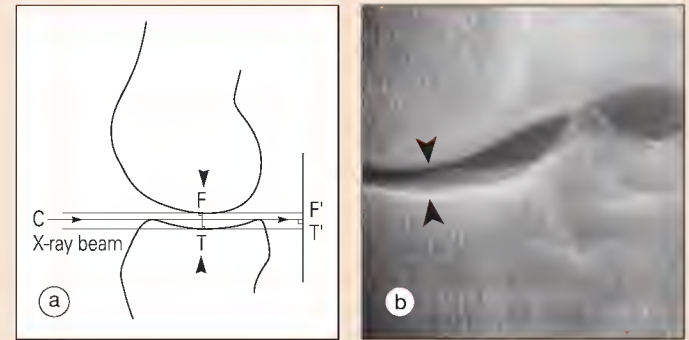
(a) For measurement of minimum joint space width in the tibiofemoral compartment, the plane is taken in the middle of the joint, coincident with load transmission (arrows), perpendicular to the central ray (C) of the x-ray beam and parallel to the film. (b) Arrowheads identify the corresponding site in the anteroposterior radiograph of an osteoarthritic knee. F, femur; T, tibia; F' and T', their projections onto the x-ray film.
